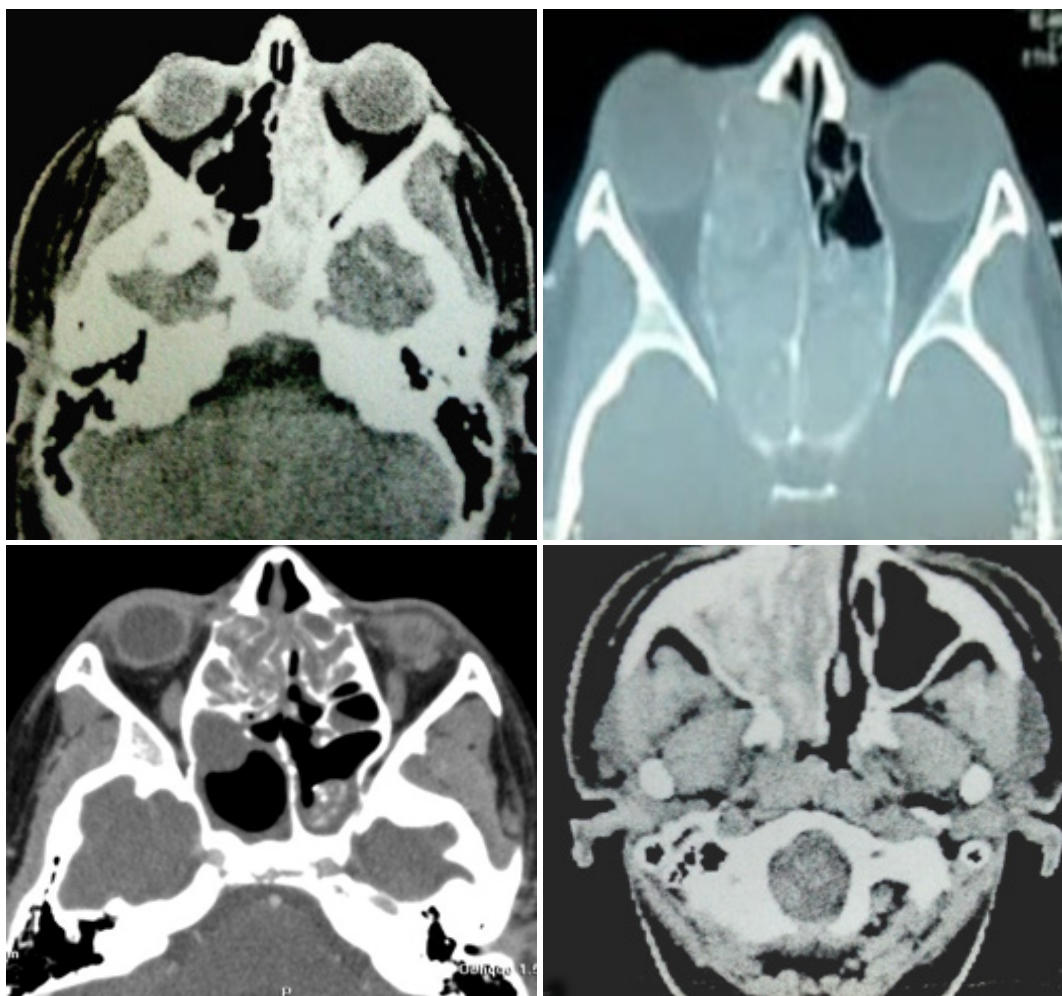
preoperative axial CT showing AFS
